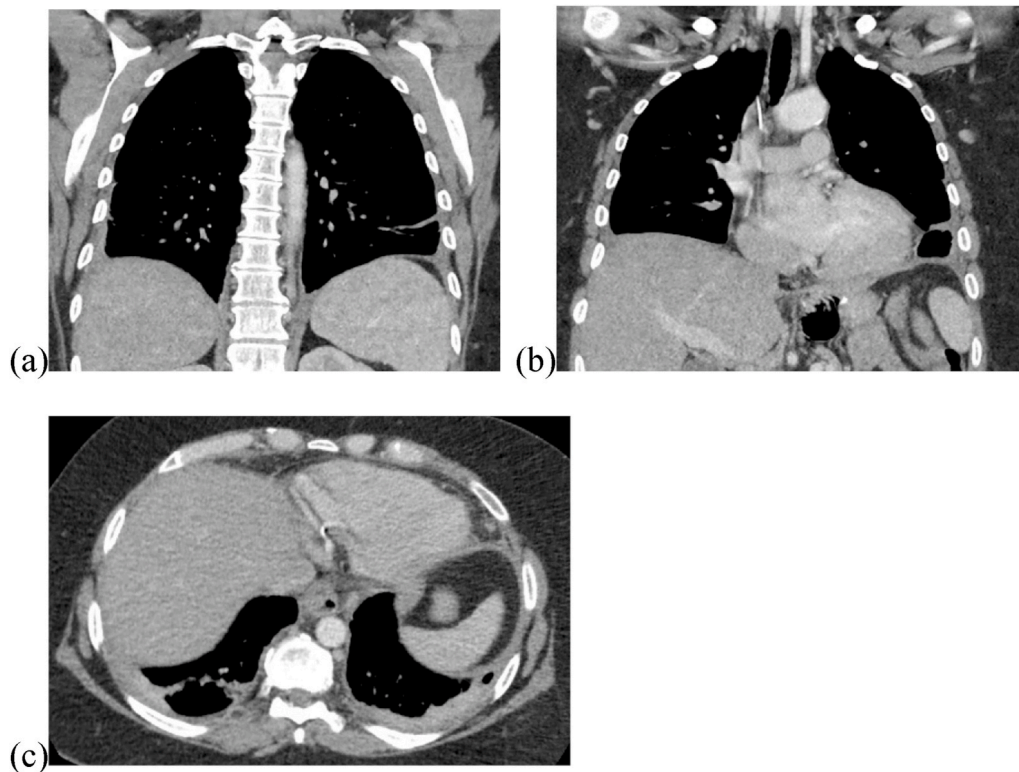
Caption: CT scan sections showing near-complete resolution of bilateral empyema after discharge with coronal (a)(b) and axial (c) views.
